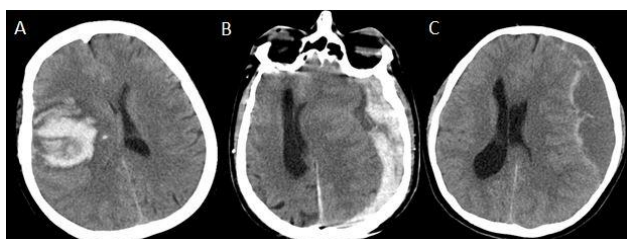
Brain CT images of patient 11, 2 and 12 shown respectively
